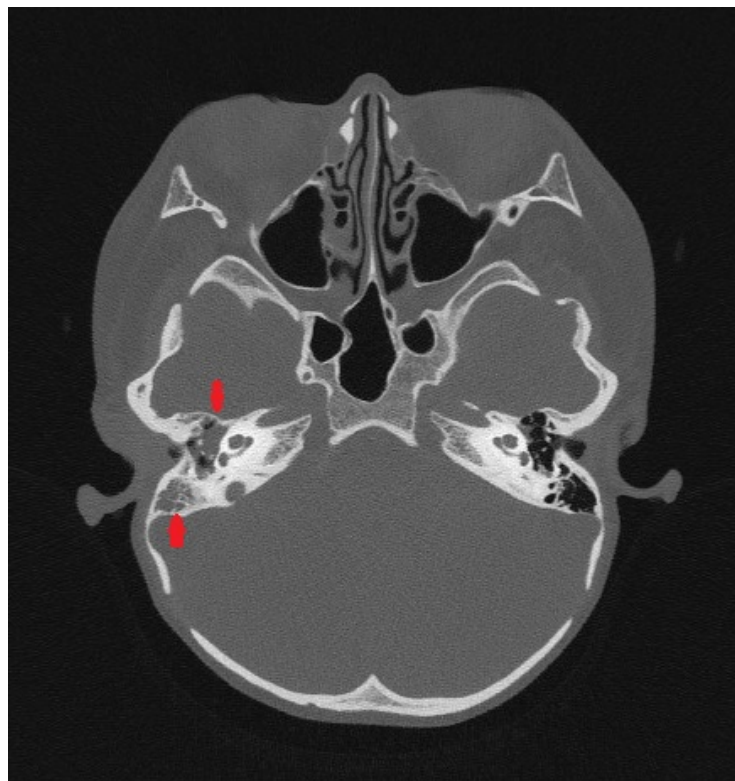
Plain computed tomography (CT) scan of the temporal bone. Red arrows point to the temporal papillae were poorly pneumatized bilaterally, with plate-barrier-type papillae.
